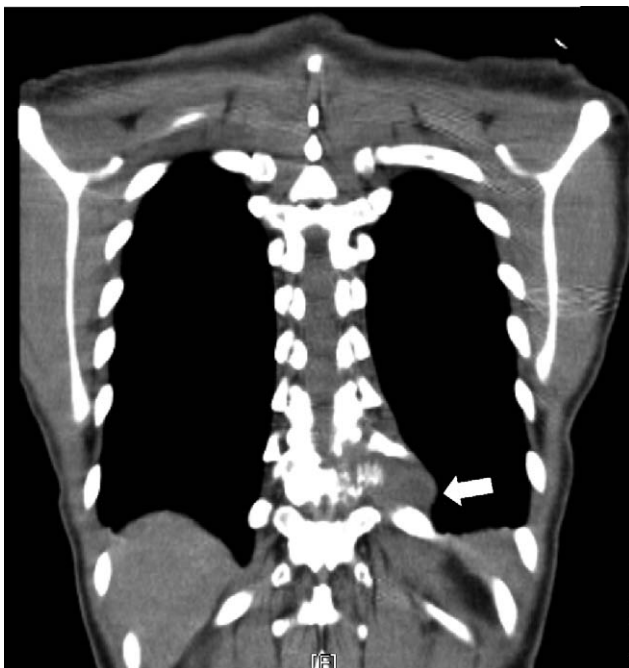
Sagittal computed tomography (CT) scan of the chest showed left paraspinal mass (3.2 × 2.9 × 1.9 cm) (white arrow).
